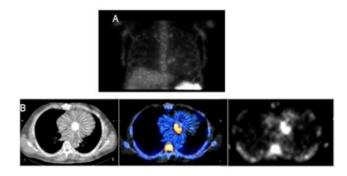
^{99m}Tc-HMPAO-WBC SPECT/CT images obtained in a patient with positive blood culture and fever arose few months after substitution of the mitral valve with a mechanical prosthesis (coronal sections in upper panel, transaxial sections in lower panel; CT images in left panels, SPECT/CT images in central panels, SPECT images in right panels). SPECT images demonstrate a clear focus of uptake in the right heart, identified as endocarditis of the native tricuspid valve by the superimposed SPECT/CT images (central panels). Endocarditis of the mechanical prosthesis, the expected site of infection before performing ^{99m}Tc-HMPAO-WBC, was therefore excluded.
